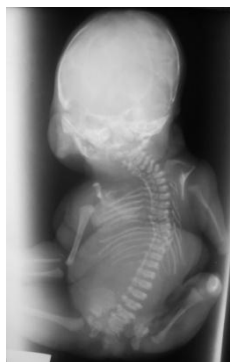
Post-natal Antero-posterior plain x-ray of the fetus: Depicts thoracolumbar kyphoscoliosis, Left upper limb only has a humerus and left lower limb only has a femur.
